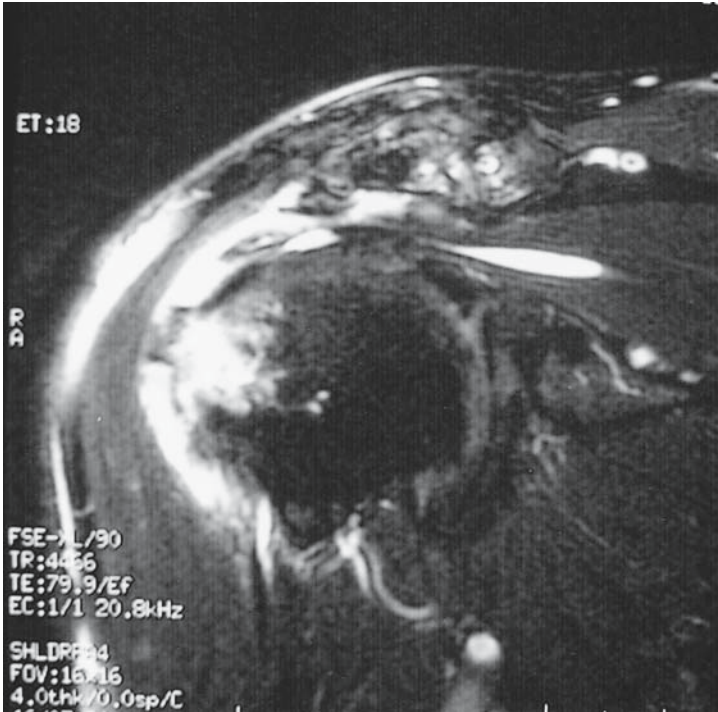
A tear of the supraspinatus tendon with fluid in the gap is easily appreciated in this coronal oblique magnetic resonance imaging (MRI) scan image of the glenohumeral joint.
